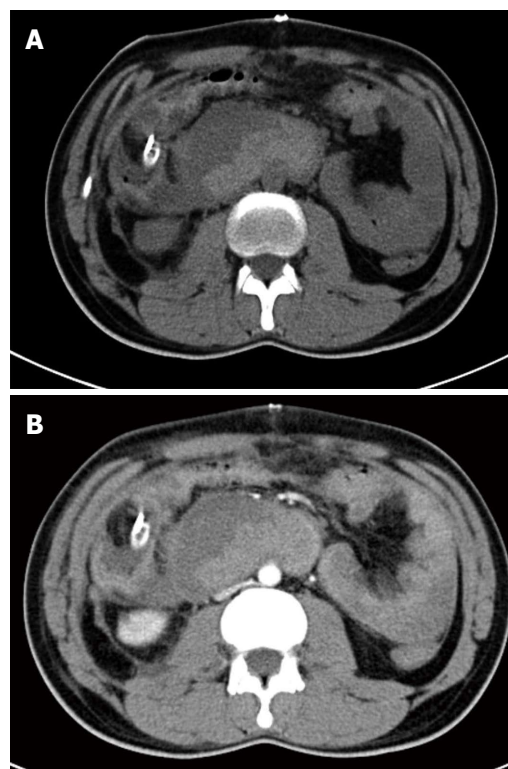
Computer tomography scan showing a primary aortoduodenal fistula between the infrarenal aorta and 4th part of the duodenum. A: Computer tomography (CT) scan without contrast showing a ruptured aortic aneurysm; B: Arterial phase of the CT scan showing the partially thrombosed abdominal aortic aneurysm.
